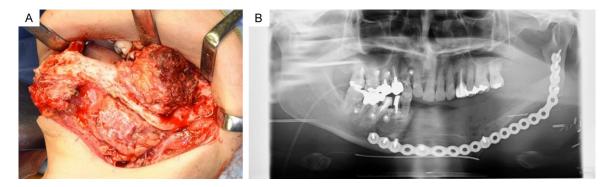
Surgical findings for the second recurrent lesion. A: The lesion on the anterior edge of the left mandibular ramus was clearly defined by including the surrounding buccinator muscle, masseter muscle, and medial pterygoid muscle on the resection side. B: Postoperative panoramic radiographic finding.
